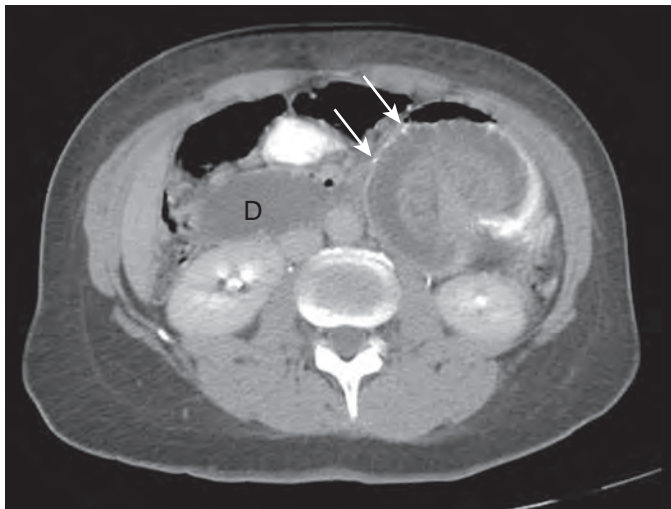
Intussusception following RYGB on CT. Axial CT scan following positive oral and IV contrast shows a fixed intussusception about the JJ anastomosis, with focal bowel dilation and dilation of the fluid-filled duodenum (D) caused by associated obstruction of the biliopancreatic limb (type B obstruction). Note anastomotic suture (arrows).
